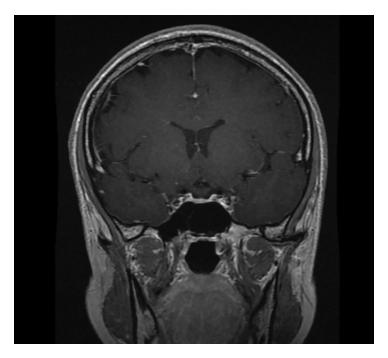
Non-contrast MRI of the head, T1 WI, coronal (frontal) projection. MR picture of partially "empty" Turkish saddle.
